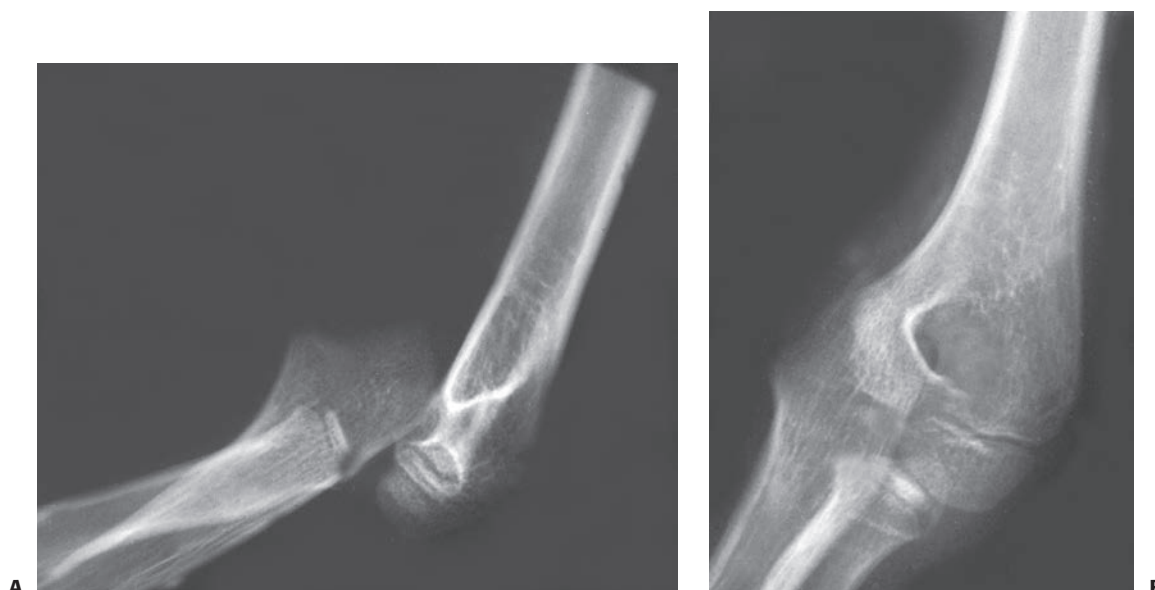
Anterior dislocation of the elbow. A: Initial anteroposterior radiograph. The olecranon lies anterior to the distal humerus. B: Initial lateral radiograph. The proximal ulna and radial head lie anteromedial, and the elbow carrying angle is in varus. (Courtesy of Hilario Trevino, MD.)
